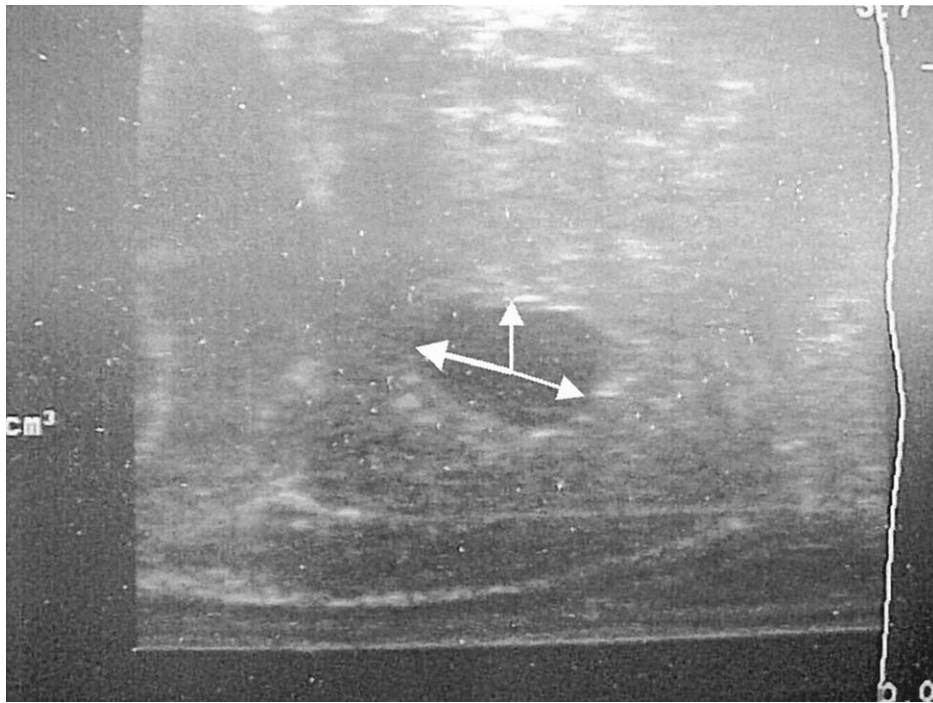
Transrectal ultrasound image showing midline sagittal view of transurethral resection of the prostate cavity.
